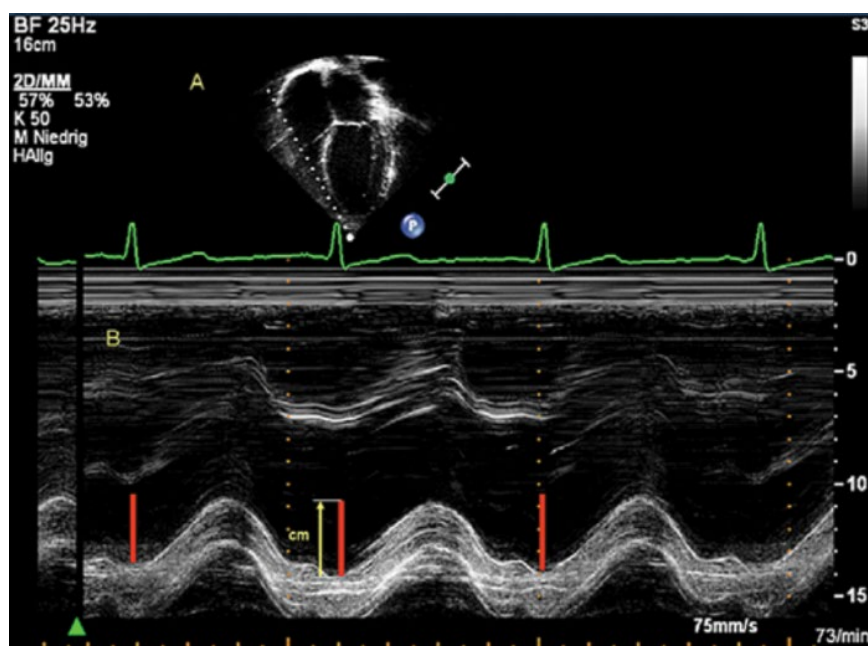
Apical four-chamber view of a transthoracic echocardiogram evaluating the right ventricle. (A) The white broken line indicates M-mode cursor placement at the tricuspid lateral annulus. (B) Representative M-mode imaging of the Tricuspid annular plane systolic excursion (TAPSE) in a patient with normal right and left ventricular function. The absolute longitudinal displacement measure (cm) is indicated by the red line. The yellow arrow marks the upper and lower measure points. *Source:* Reproduced from Koestenberger et al [57] with permission of Elsevier.
